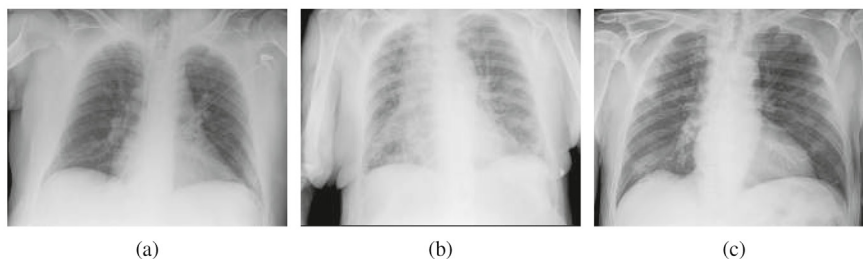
Examples of portable chest X-ray images of 3 different classes. (a) Normal class. (b) Pathological class. (c) COVID-19 class.
